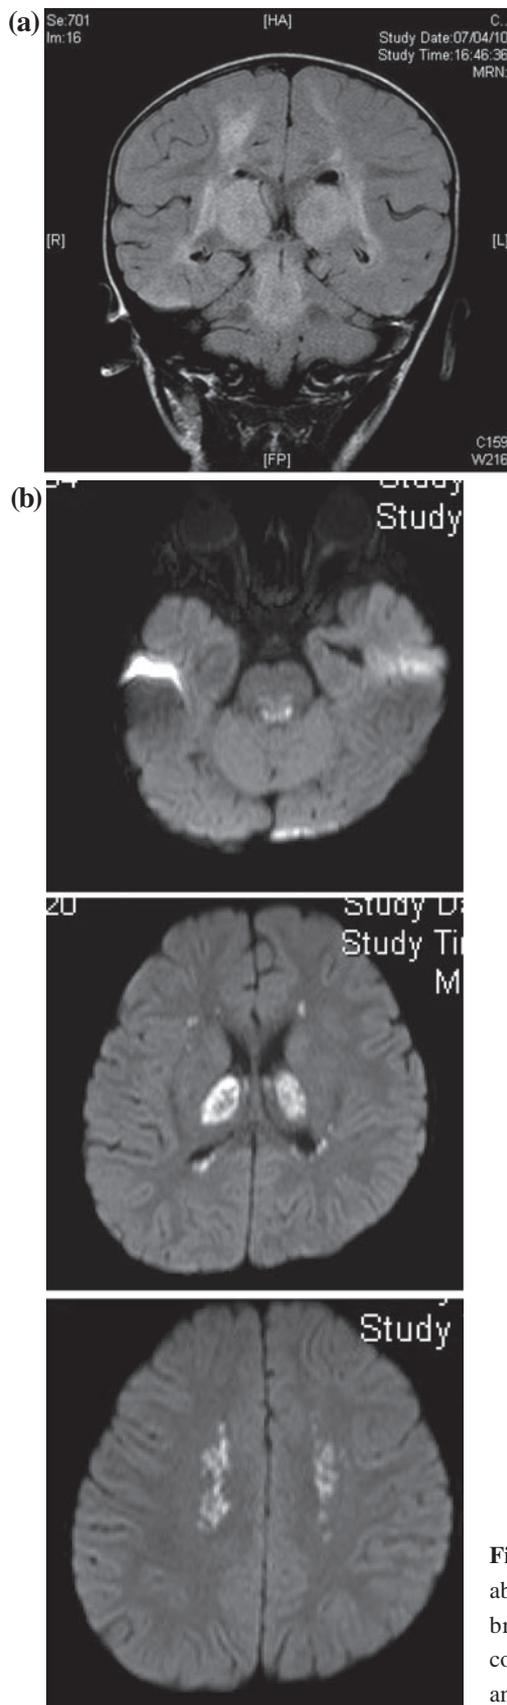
(a) Initial MRI performed on day 3. Coronal FLAIR image demonstrated abnormal hyperintense T2 signal in periventricular white matter, bilateral thalami and brainstem. (b) Diffusion weighted images showed restricted diffusion in the corresponding areas in the posterior pons, bilateral thalami, periventricular white matter and centrum semi ovale.
